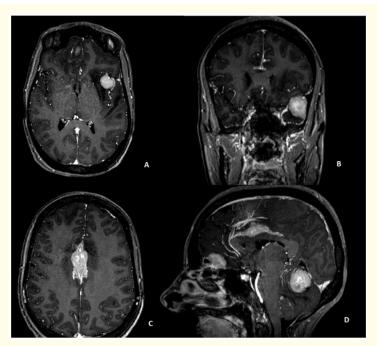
(A, C): MRI in axial section after injection of gadolinium, B: coronal section, D sagittal section: showed the dural-based lesions with intense and homogenous enhancement.
